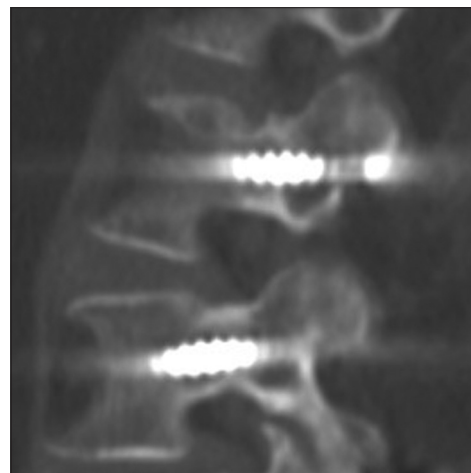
(left) Nine-month postoperative axial computed tomography showing complete fusion of pedicle fractures
